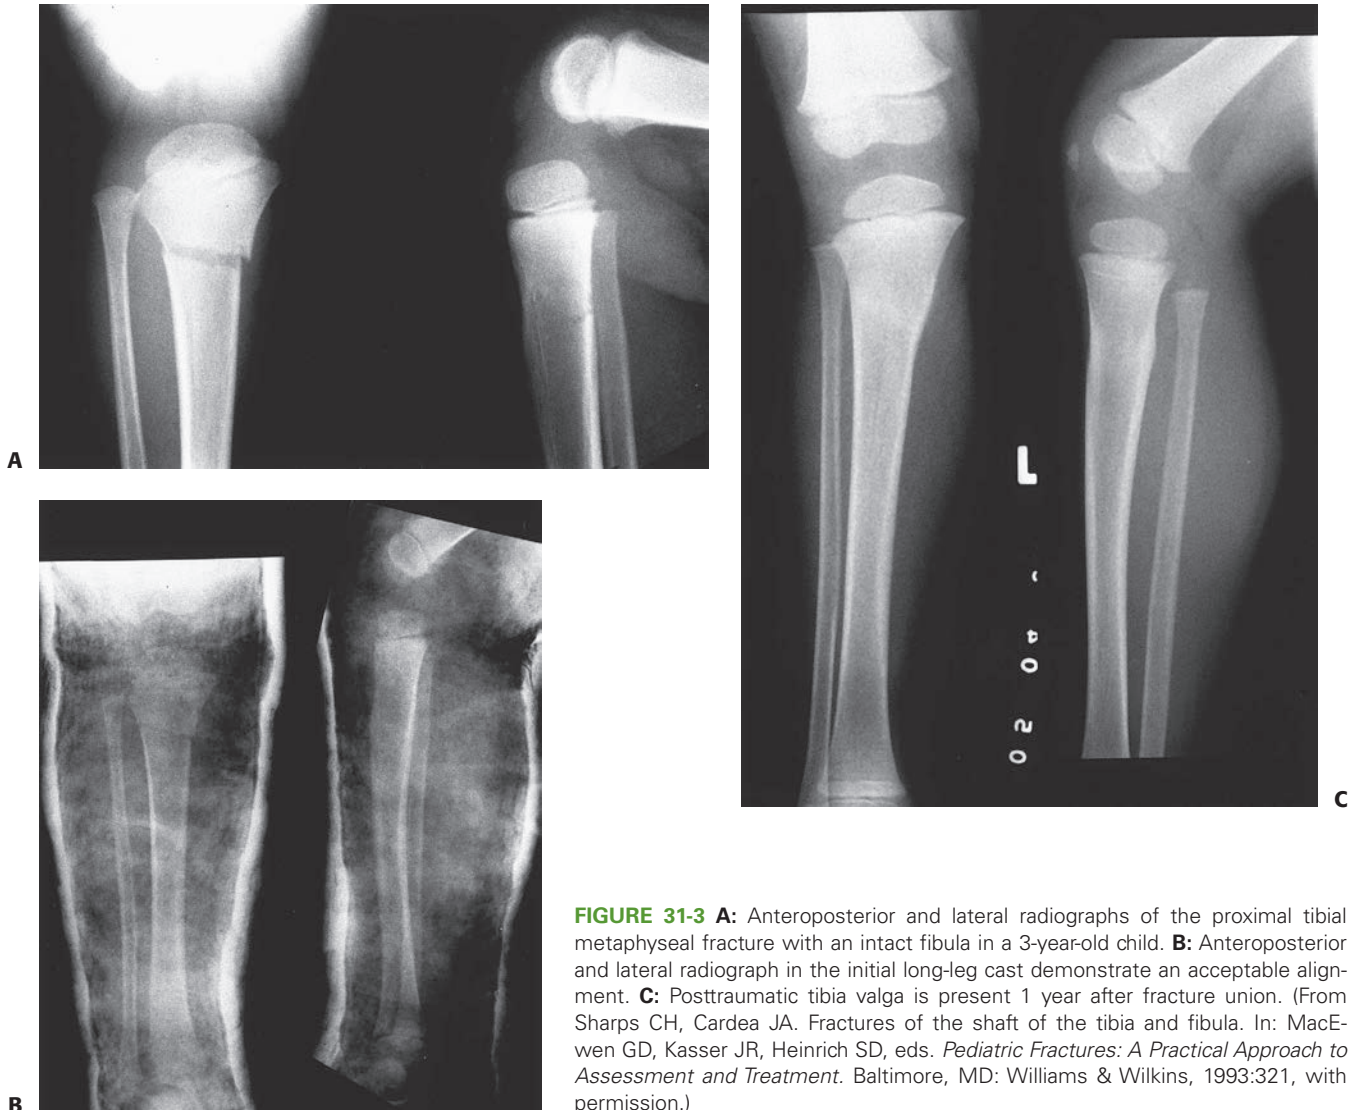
A: Anteroposterior and lateral radiographs of the proximal tibial metaphyseal fracture with an intact fibula in a 3-year-old child. B: Anteroposterior and lateral radiograph in the initial long-leg cast demonstrate an acceptable alignment. C: Posttraumatic tibia valga is present 1 year after fracture union. (From Sharps CH, Cardea JA. Fractures of the shaft of the tibia and fibula. In: MacEwen GD, Kasser JR, Heinrich SD, eds. *Pediatric Fractures: A Practical Approach to Assessment and Treatment*. Baltimore, MD: Williams & Wilkins, 1993:321, with permission.)
